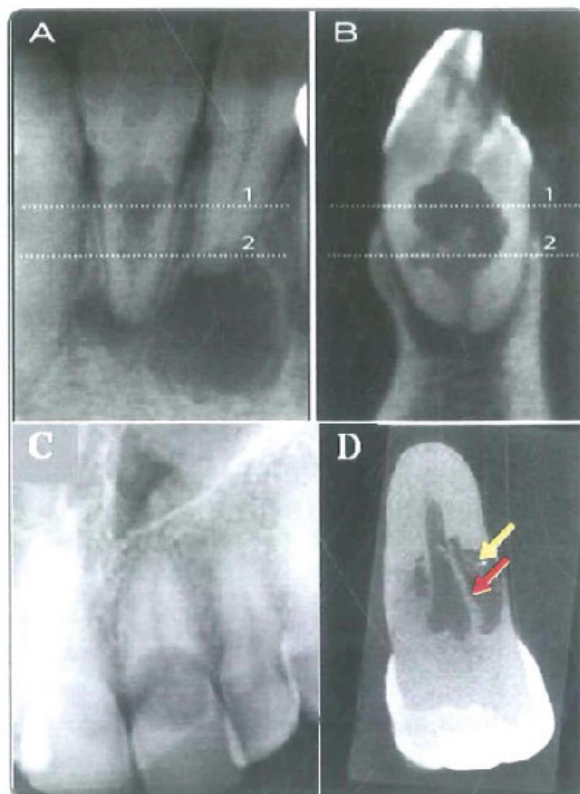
Radiographic appearance of internal resorption (A) and external resorption (C) that were confirmed by CBCT (B and D) respectively
